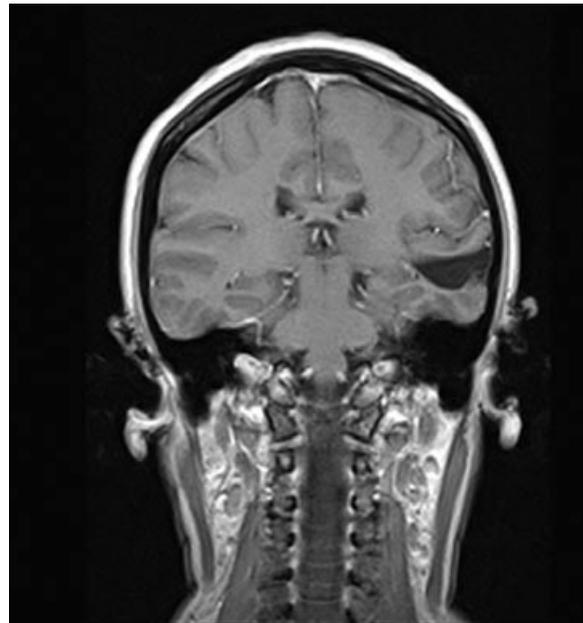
MRI, T1-weighted image, coronal projection: closed fissure in left temporal lobe.
